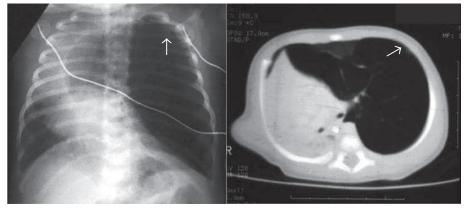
Chest X-ray: Left upper lobe CLE
